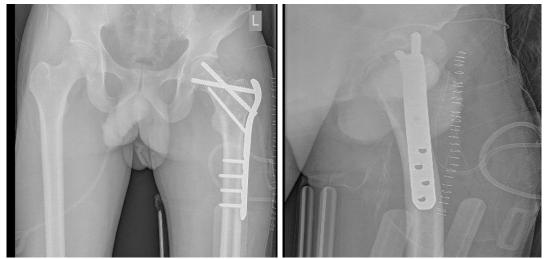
4 months follow-up Hip and Pelvis X-ray (AP and Lateral)
